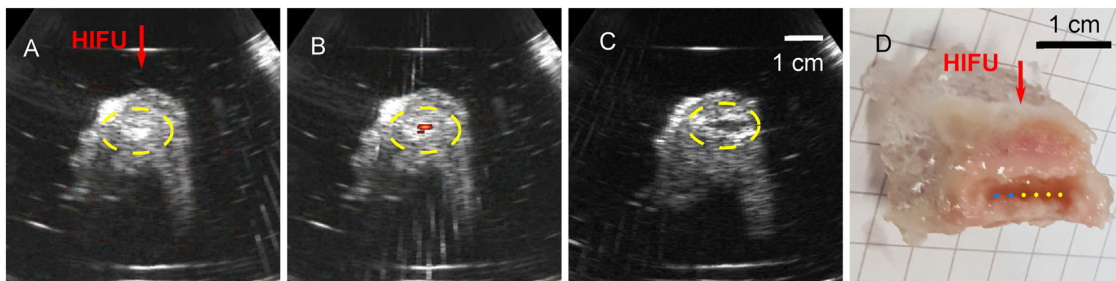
(a) Appearance of hyperechoic regions on B-mode and (b) power Doppler images during boiling histotripsy (BH) exposures. (c) Hypoechoic appearance of a volumetric lesion of merged BH lesions on B-mode images 15 min after BH exposure. (d) Bisected BH lesion consisting of one line of six discrete foci with 2-mm spacing. Two foci on the left were irradiated with 30 pulses/point (blue dots), and four foci on the right with 100 pulses per point (yellow dots), resulting in larger lesions. The red arrow indicates the direction of BH administration.
